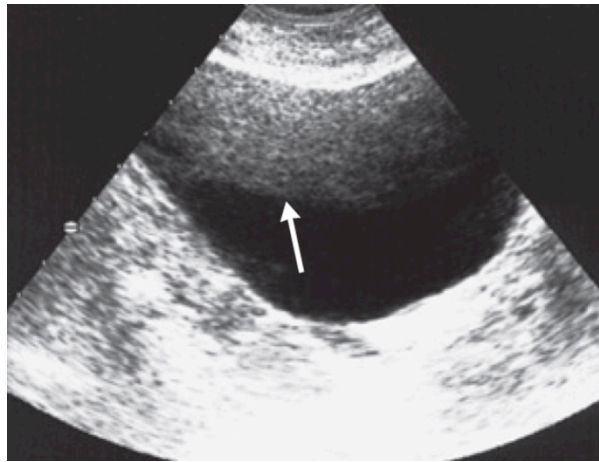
Noise (arrow) in the ultrasonographic image.
